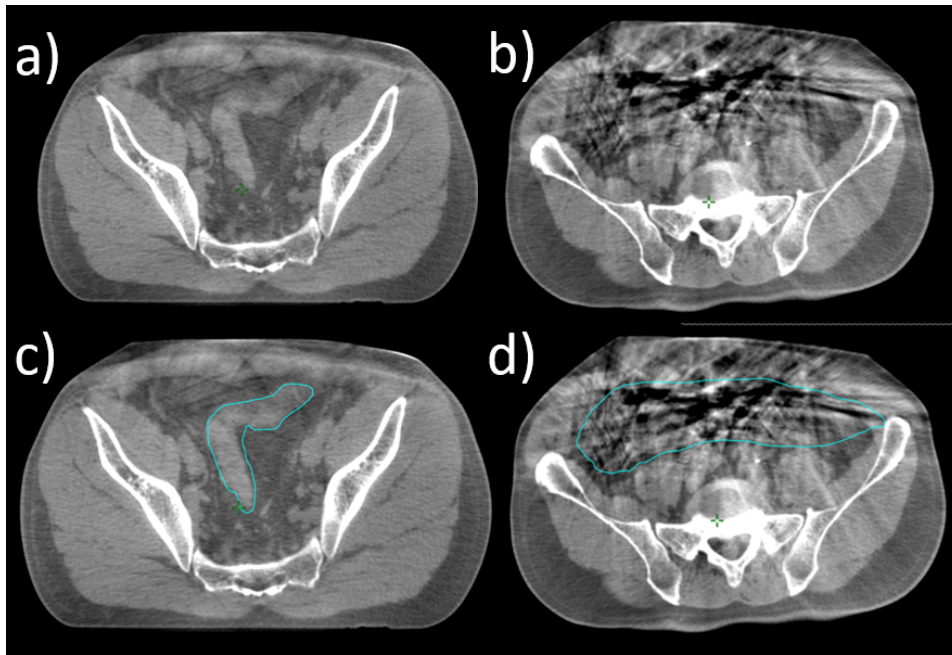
a) CBCT image slice of a patient where the amount of artifacts are limited, giving a clear sight of the bowel loops. b) CBCT of the same patient but higher up in the cranial direction. This CBCT image is more affected by artifacts making it hard to identify the bowel loops. c) Delineation of bowel loop. d) The bowel included in a bowel bag structure due to artifacts.
